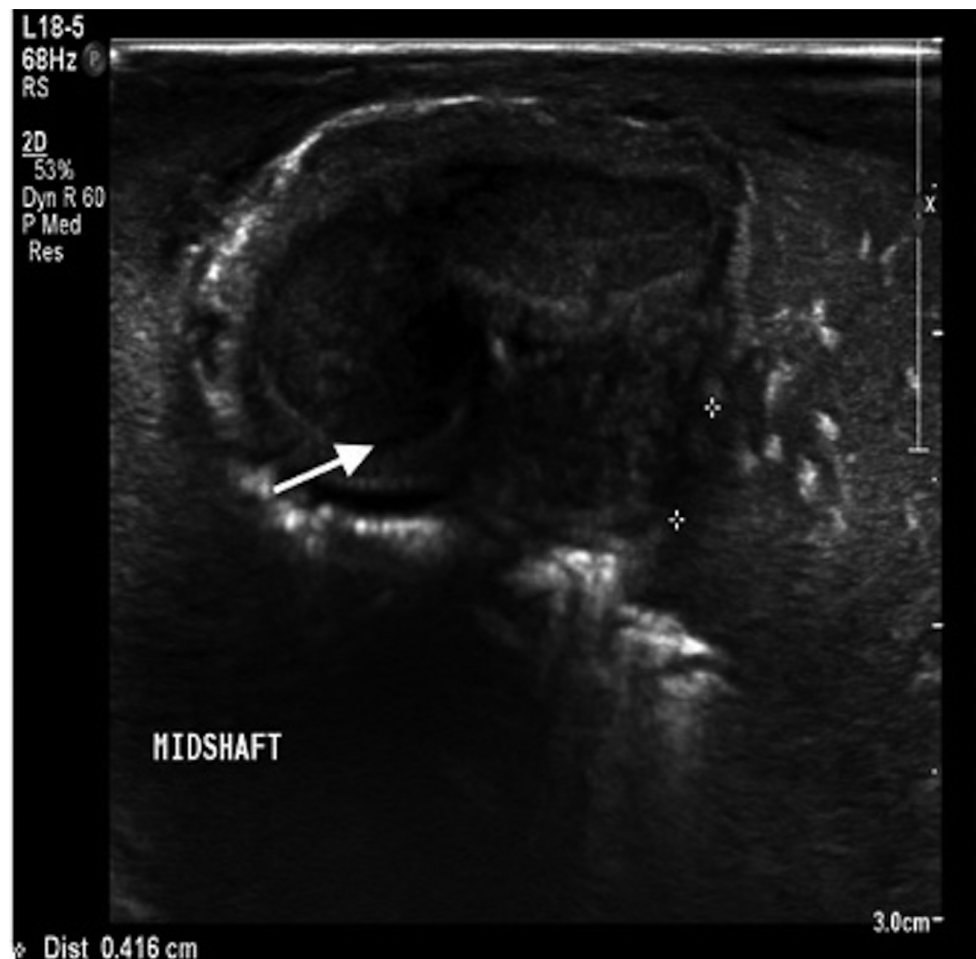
Ultrasound image of the penis in cross section, showing the haematoma (arrow) and surgical emphysema at the site of fracture.
